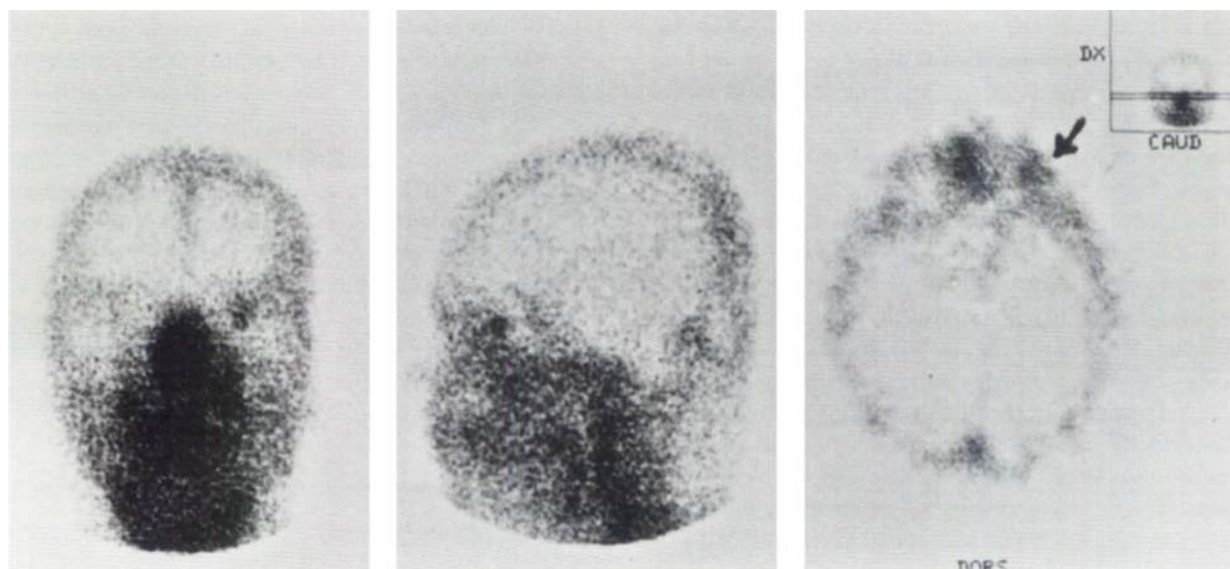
Localization of choroidal melanoma in left eye of a male patient aged 47 using ^{99m}Tc -labeled monoclonal antibody to a melanoma-associated antigen 4–5 h after intravenous administration of antibody. Gamma camera imaging in anterior (left panel) and left lateral projections (middle panel) and single photon emission computed tomography (SPECT, right panel) were performed with a parallel hole collimator.
